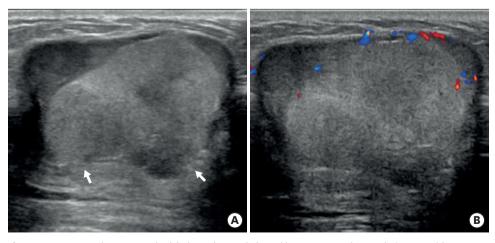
Transverse ultrasonography (A) showed an oval-shaped heterogeneous hyperechoic mass with an indistinct margin (arrows). Color Doppler image of the mass (B) showed internal and peripheral vascularity.
